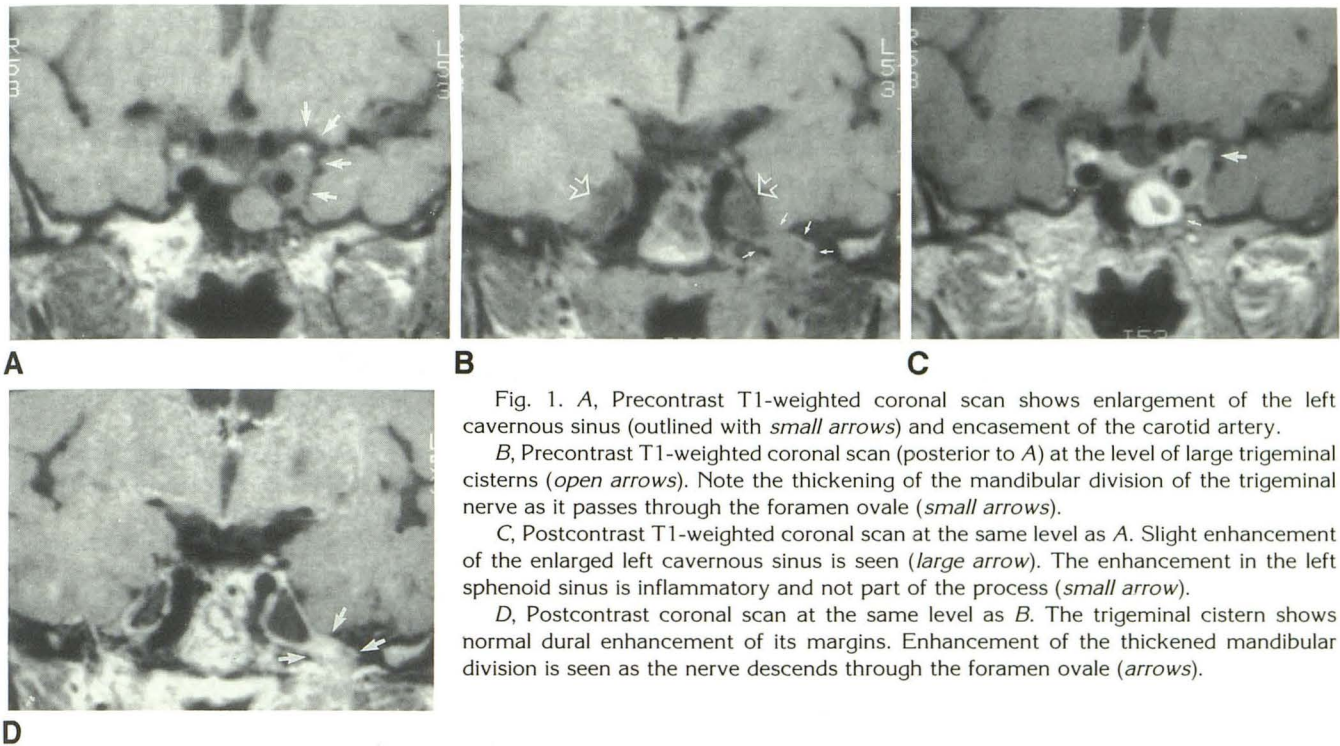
A, Precontrast T1-weighted coronal scan shows enlargement of the left cavernous sinus (outlined with *small arrows*) and encasement of the carotid artery.
